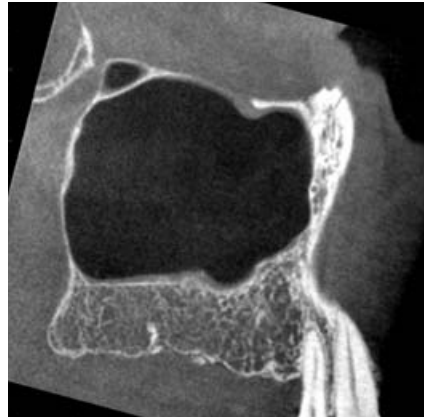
Sagittal CBCT slice
